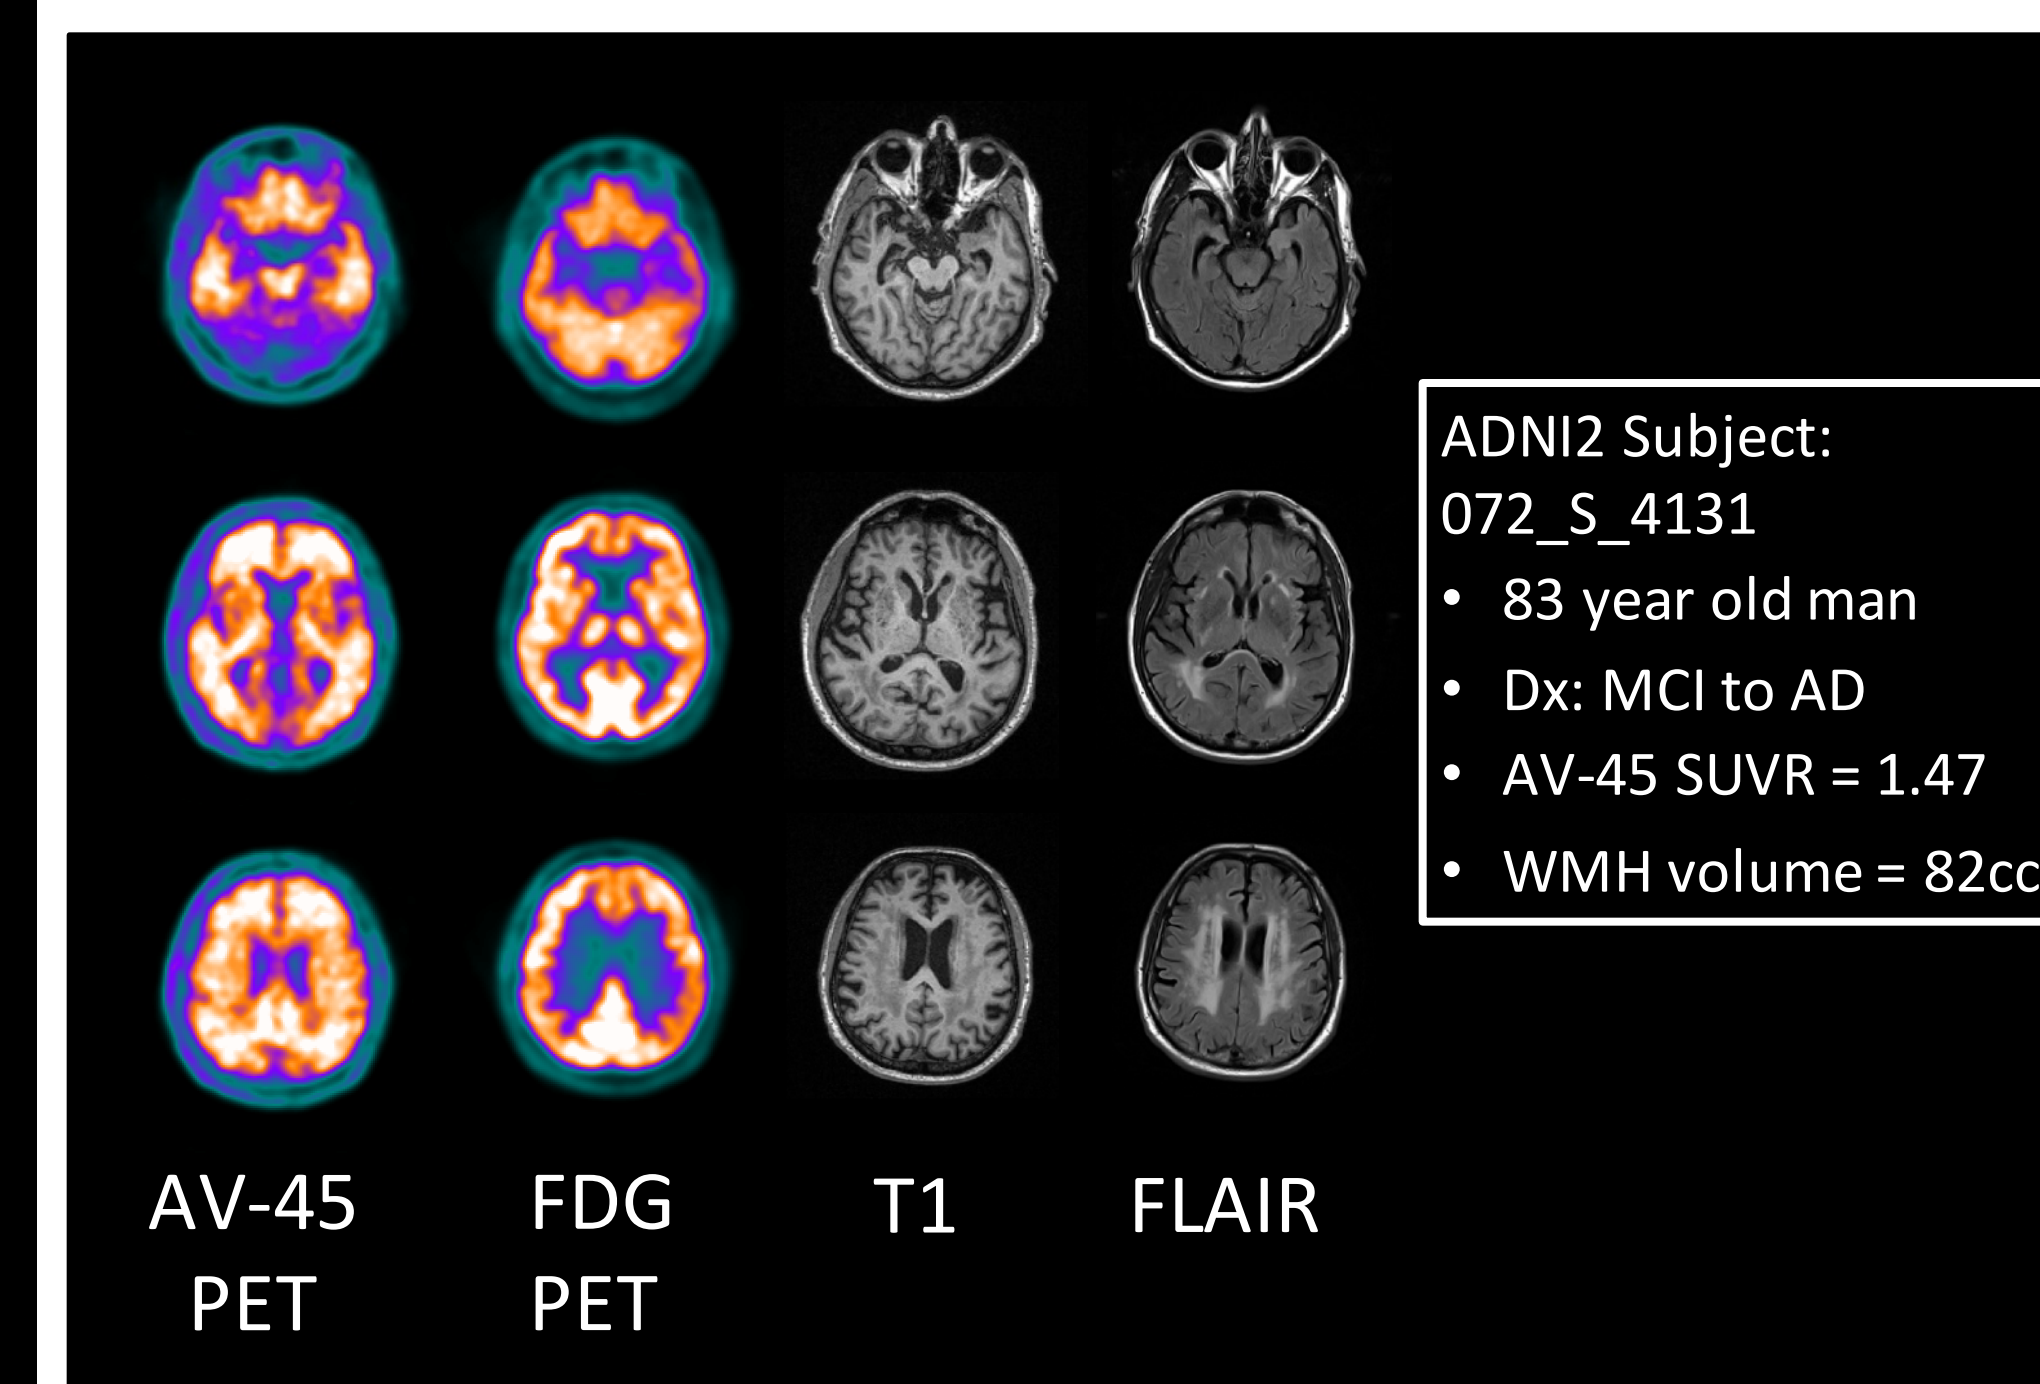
FDG and AV-45 PET and MRI examples from an ADNI subject
